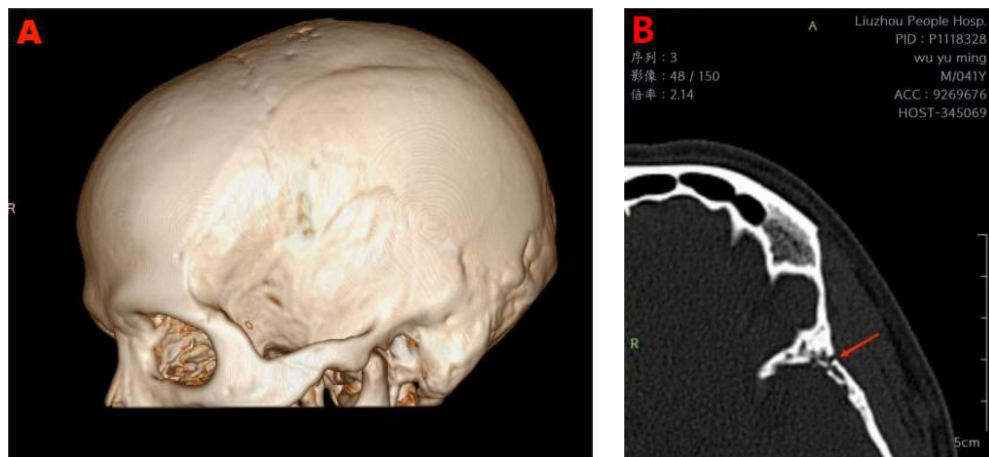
A shows the non-contrast CT scan of the head taken on May 18, 2023, and B displays the three-dimensional reconstruction image
